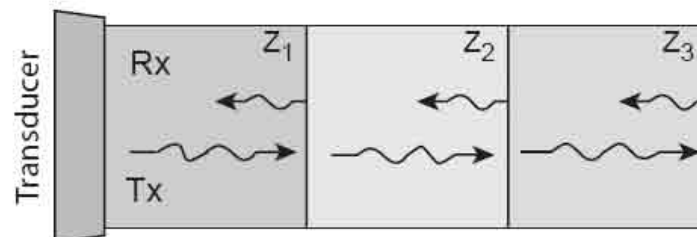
A transducer emits ultrasound pulses which are scattered when changes in acoustic impedance are met (Z_i). The backscattered signal is received by the transducer and its amplitude, frequency or phase content is used to form the image. This figure was adapted from [26].
